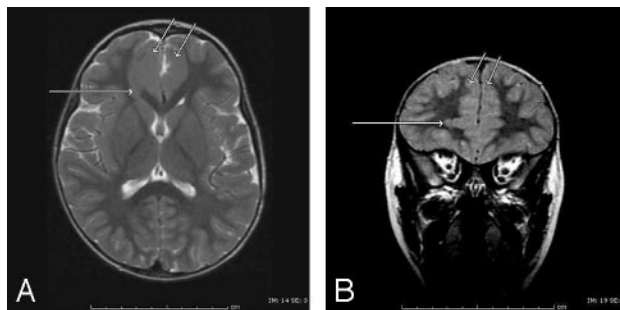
A, Axial T2-weighted image reveals thickening of the cortical gray matter at the medial aspect of both frontal lobes, compatible with bifrontal cortical dysplasia (short arrows). Also seen is a strip of ectopic gray matter extending from the head of the right caudate nuclei to the orbitofrontal cortex (long arrow).
